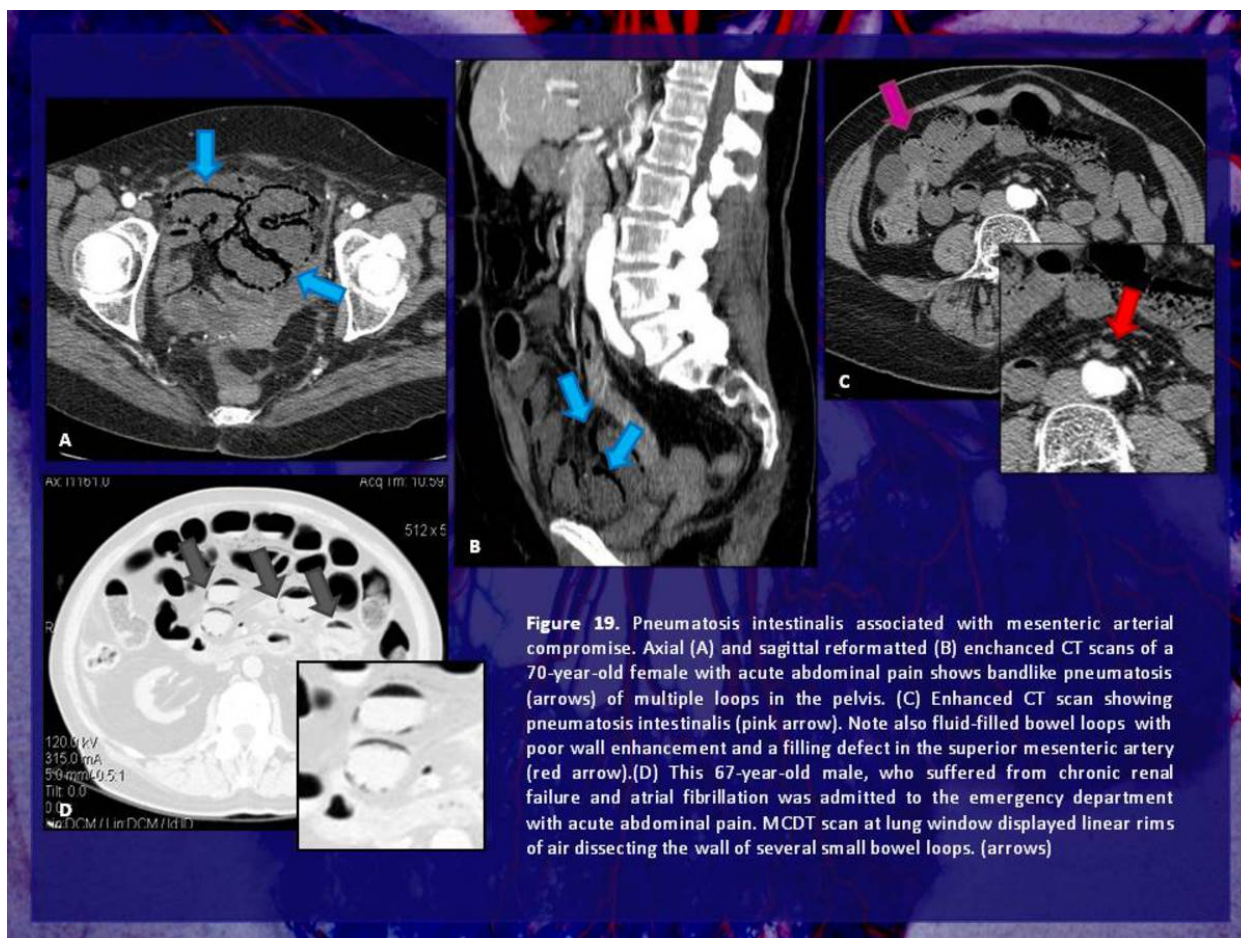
Pneumatosis intestinalis associated with mesenteric arterial compromise. Axial (A) and sagittal reformatted (B) enhanced CT scans of a 70-year-old female with acute abdominal pain shows bandlike pneumatosis (arrows) of multiple loops in the pelvis. (C) Enhanced CT scan showing pneumatosis intestinalis (pink arrow). Note also fluid-filled bowel loops with poor wall enhancement and a filling defect in the superior mesenteric artery (red arrow). (D) This 67-year-old male, who suffered from chronic renal failure and atrial fibrillation was admitted to the emergency department with acute abdominal pain. MCDT scan at lung window displayed linear rims of air dissecting the wall of several small bowel loops. (arrows)
